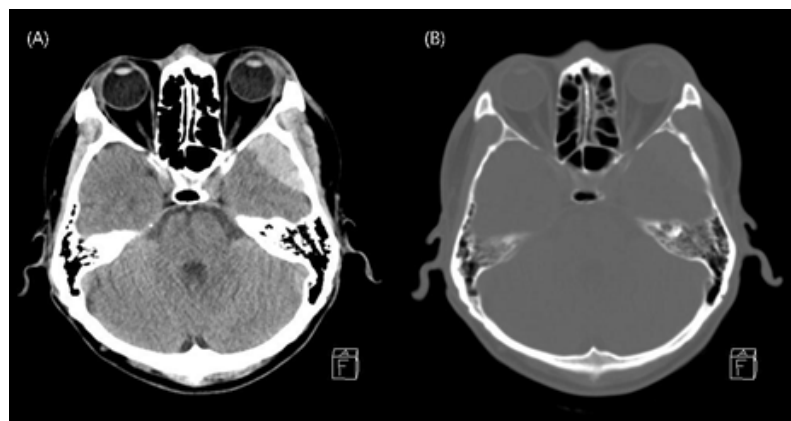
This is a transverse brain computed tomography(CT) image taken before surgery. (A) Hemorrhage can be observed inside the temporal bone. (B) A fracture of the temporal bone is observed in image.
